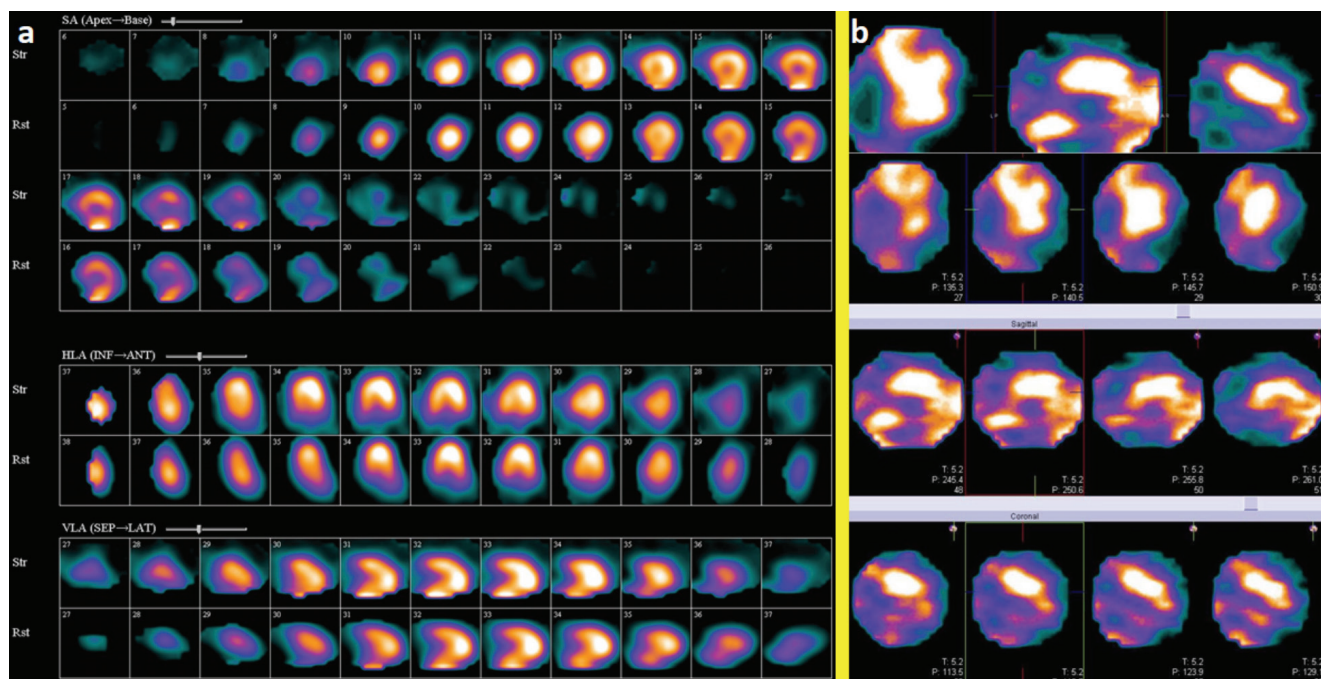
A 21-year-old male patient was admitted in our hospital for mild chest discomfort since 1 month ago and a 2-mm ST-segment elevation in all leads, except in AVR and V1. His workup was performed elsewhere. At that time, he experienced severe acute chest pain accompanied by dyspnea. The patient was afebrile. He had no history of a viral or other infection and drug abuse. On history assessment, he had tachycardia, and his blood pressure was in the normal range. Cardiac laboratory tests, especially troponin and creatine kinase, were markedly elevated, while an echocardiographic examination was unremarkable with an ejection fraction of 55%. The patient has received high-dose anti-inflammatory drugs, which was probably associated with acute pericarditis. The aforementioned cardiac biomarkers decreased gradually within a few days of admission, and the patient was discharged that time.
